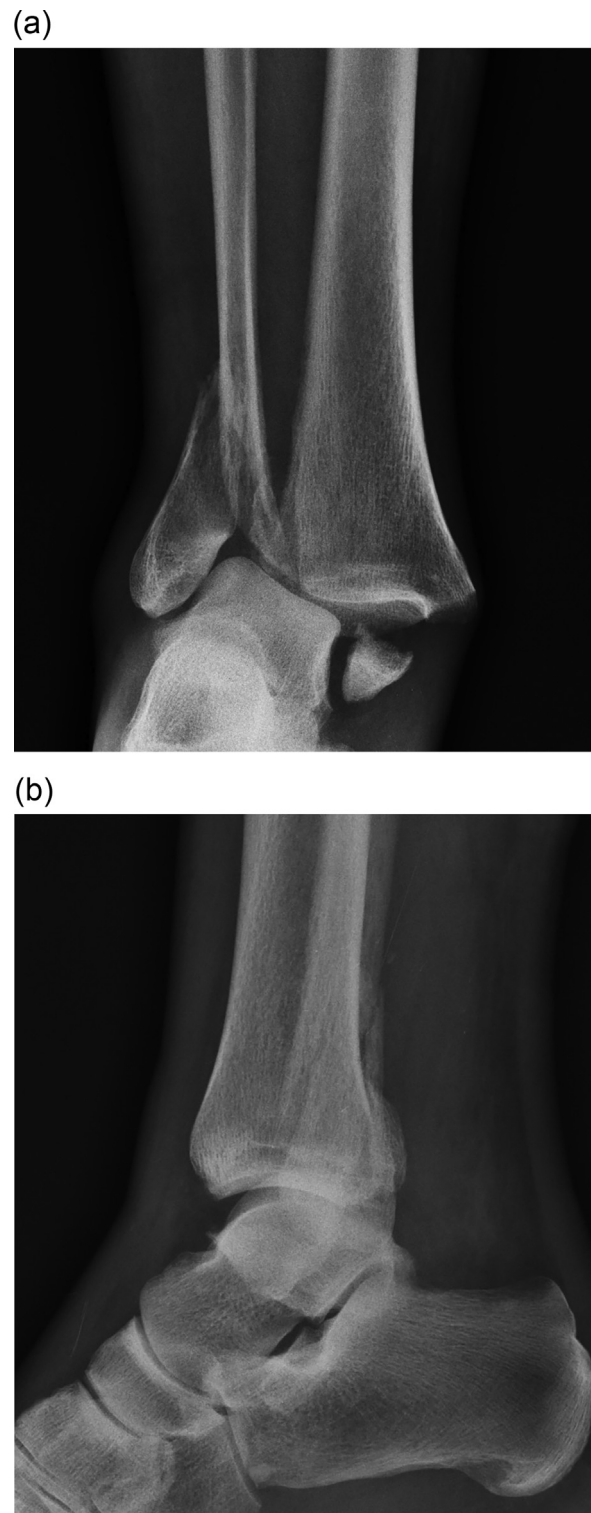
Example of SER-type fracture X-ray – (a) mortise and (b) lateral. This patient sustained fracture while biking, in pronatory mechanism (toes striking the obstacle with the foot on the pedal).
